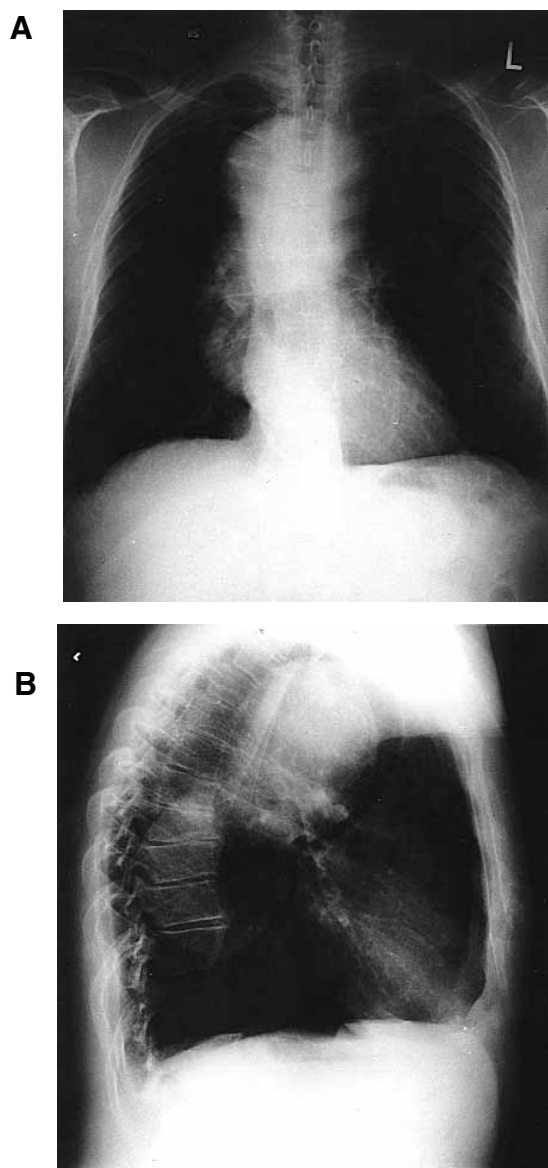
Chest radiograph. Large circumscribed mass projects on right and left hemithorax (A) and in posterior-superior mediastinum, with compression of trachea (B).
